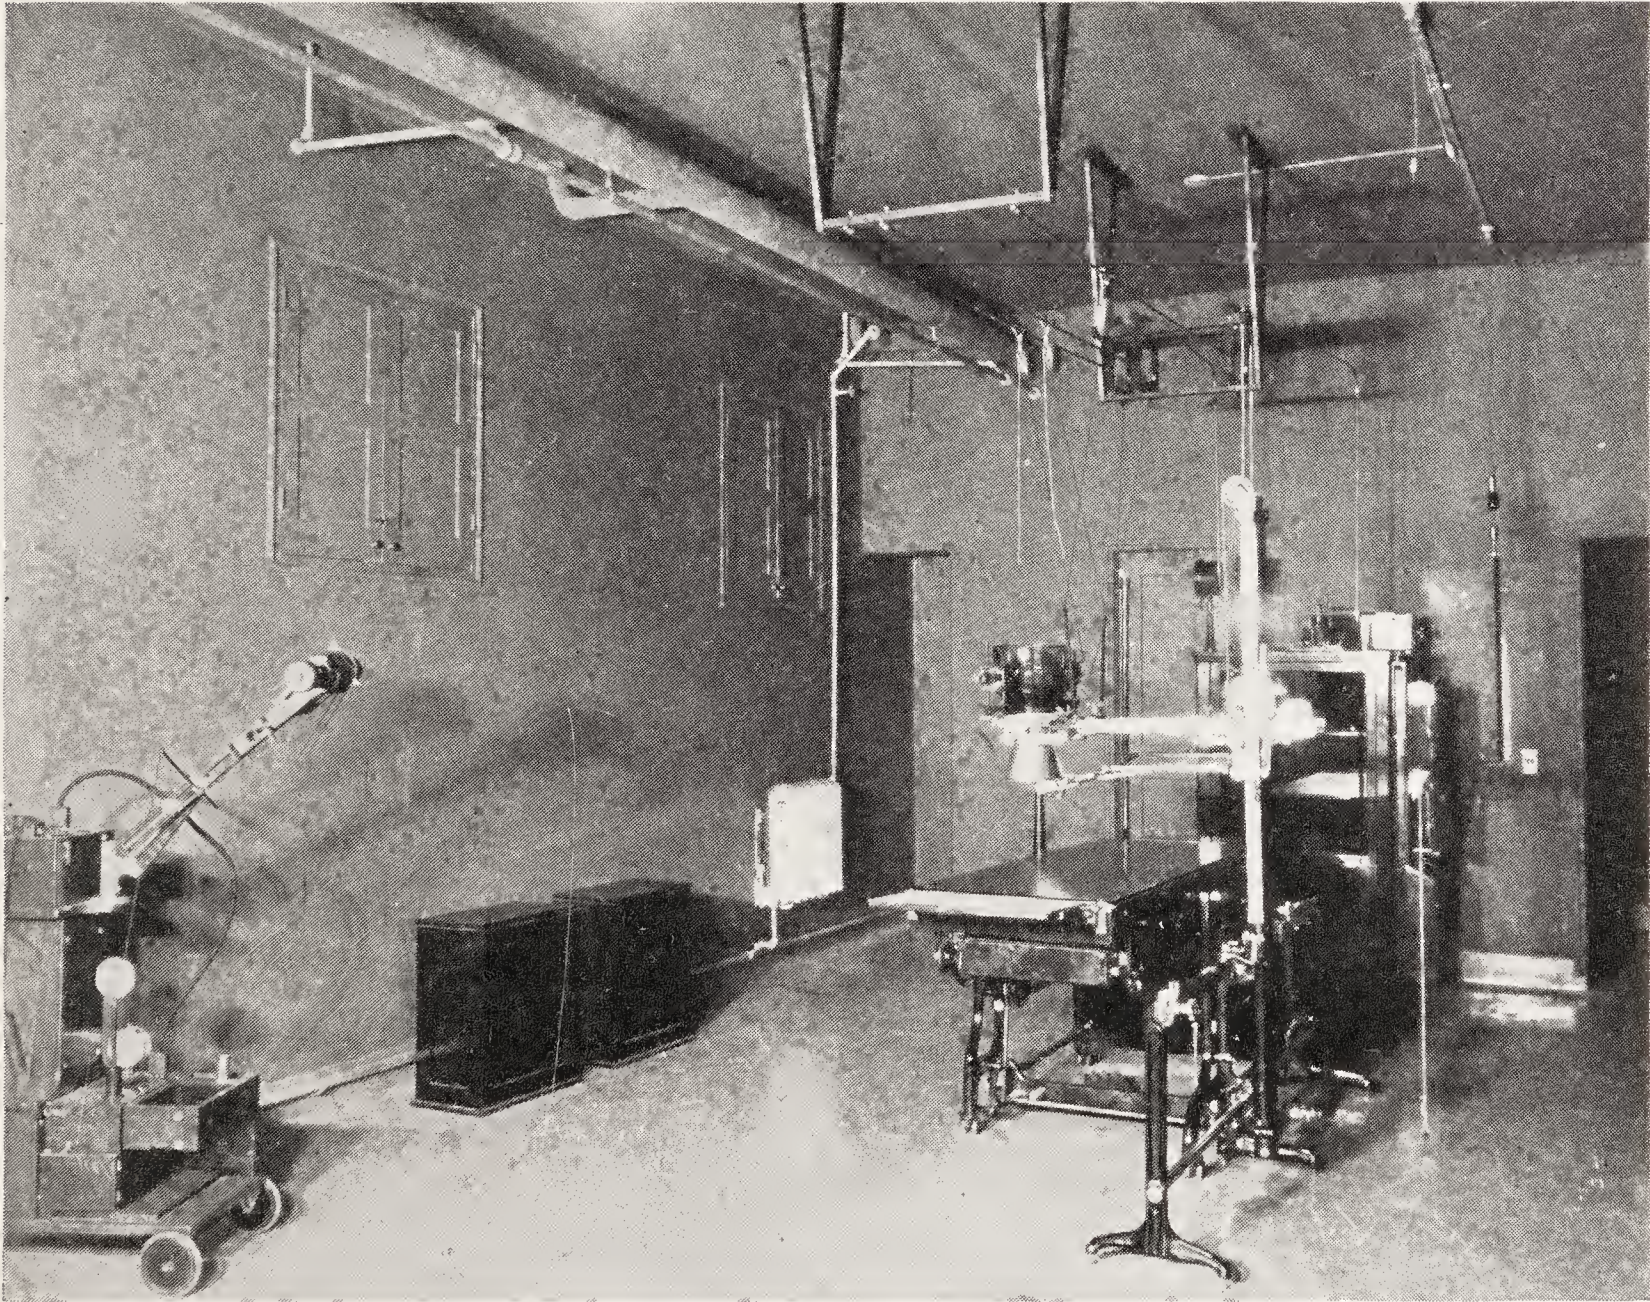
RADIOGRAPHY ROOM, EVERETT GENERAL HOSPITAL, EVERETT, WASH.
